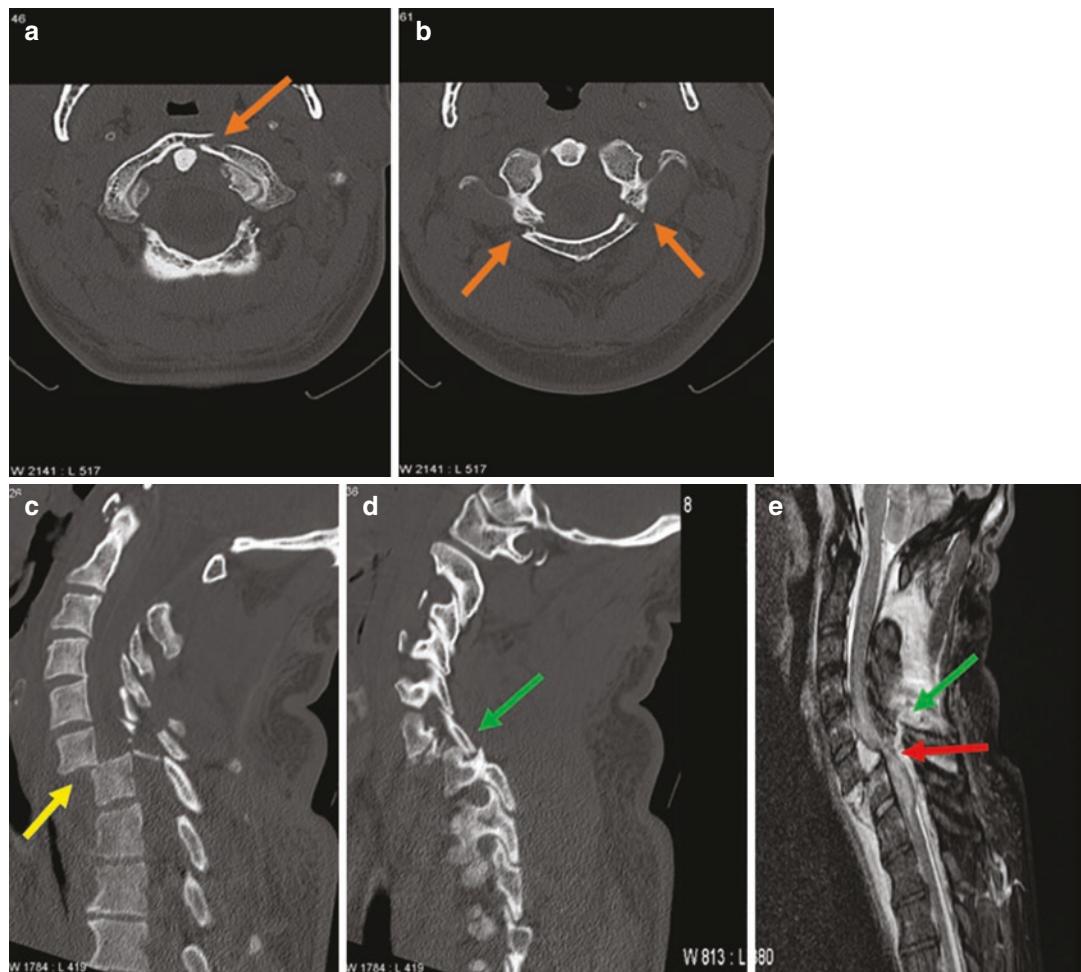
A 41-year-old jogger with history of polytrauma after a tree fell on him, with an axial loading mechanism. CT cervical spine (a, b) axial images with a three-part atypical Jefferson fracture, with single fracture through the anterior arch, and bilateral fractures through the posterior arch of C1 (orange arrows). (c) Sagittal plane
